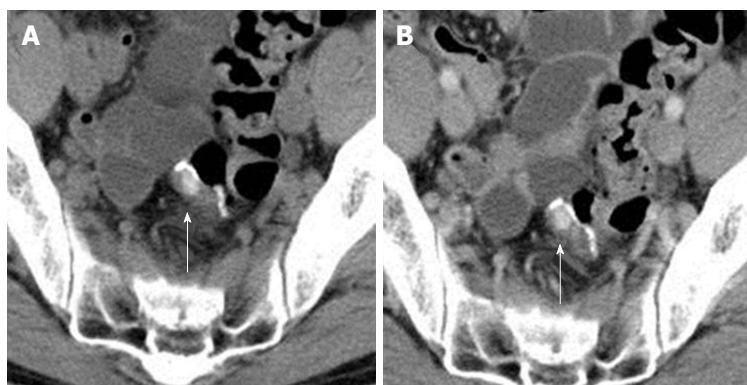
Un-enhanced and intravenous contrast-enhanced computed tomography scans of the abdomen show a slightly hyperdense mass in the rectal wall without contrast enhancement (white arrow). A: Unenhanced CT; B: Contrast enhanced CT. CT: Computed tomography.
